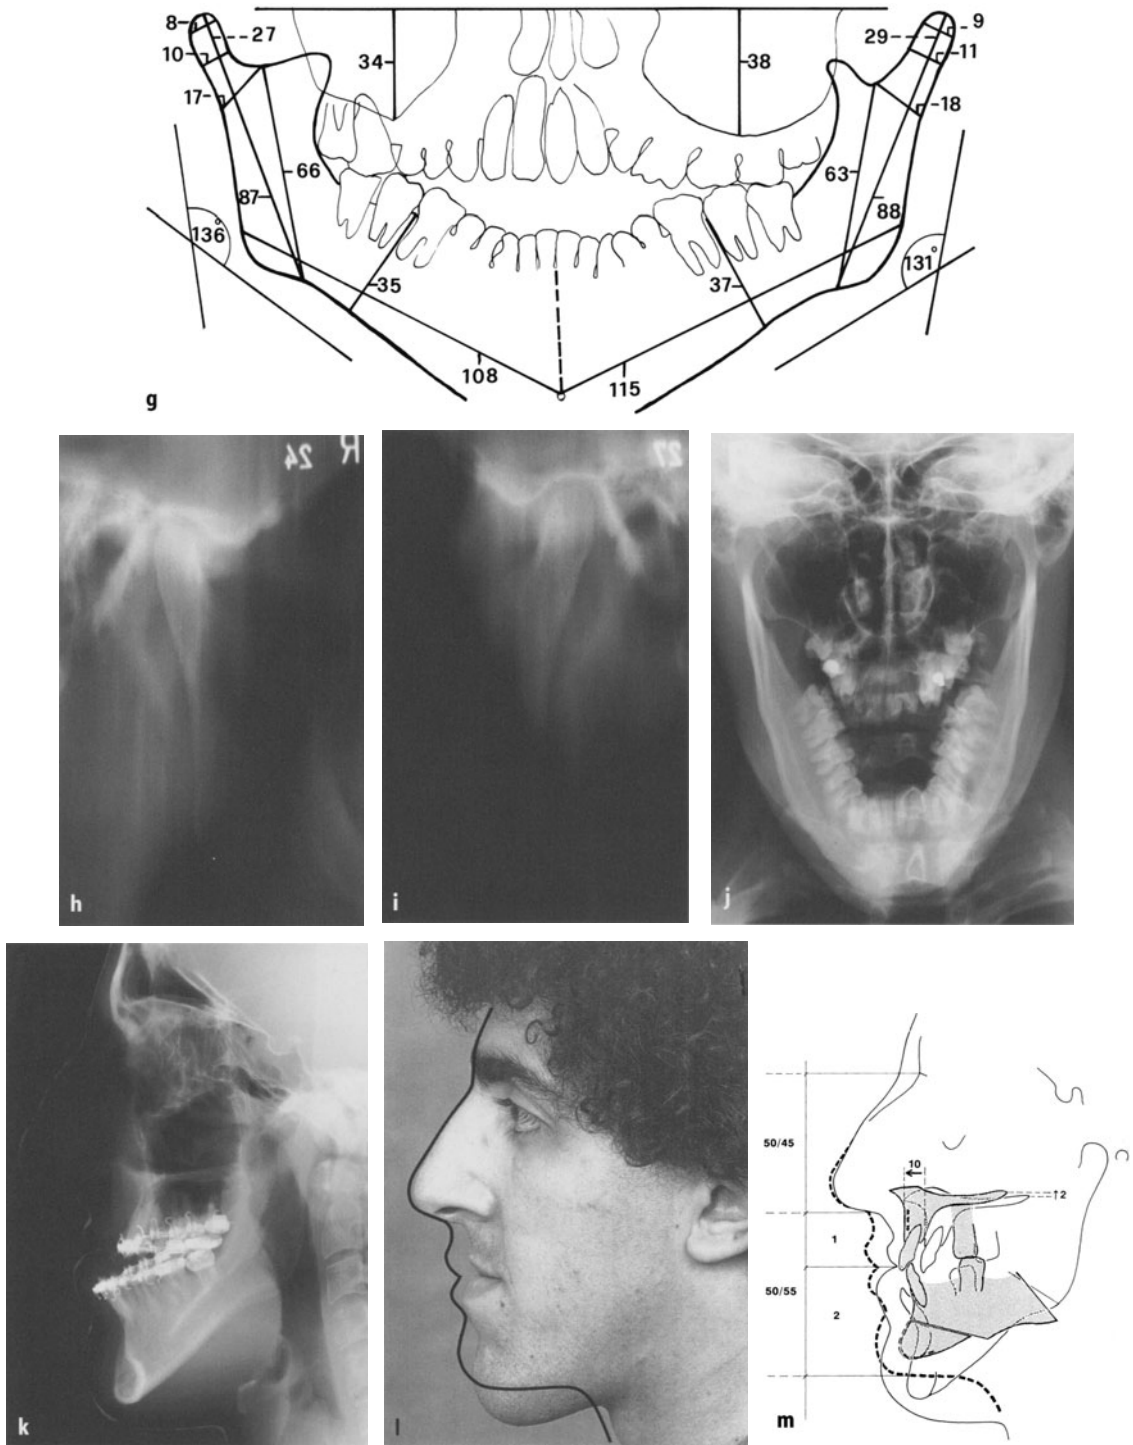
Bilateral non-slender H.E. producing a severe open bite. g The tracing of this radiograph cannot give the answer to the question why that kink has occurred. h, i The TMJ-ramus tomograms do not disclose anything of note. j The mandible in p.a. projection does not disclose any great difference between left and right sides. Both ascending rami seem remarkably longer than normal. k The lateral cephalogram after presurgical orthodontics demonstrates the enormous contrast between the long and straight mandible and the repositioned maxilla with its short base. l Original and planned profile lines. m The planned profile superimposed on the cephalometric tracing. Maxilla, mandible and chin moved into the desired position
